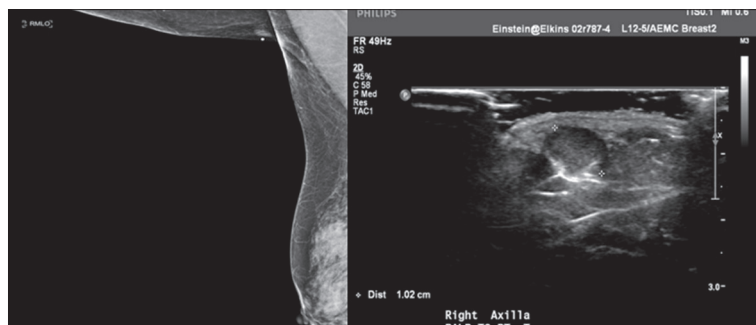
Preoperative imaging. Preoperative mammography noted no primary within the breast, while axillary ultrasound demonstrated a subcutaneous nodule that was subsequently noted to be a primary ectopic breast carcinoma.
